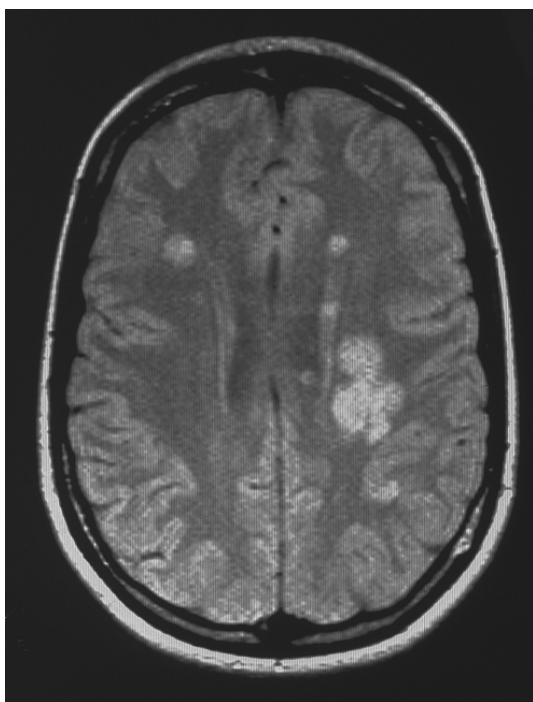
MRI scan of one of our patients with clinically significant multiple sclerosis.
